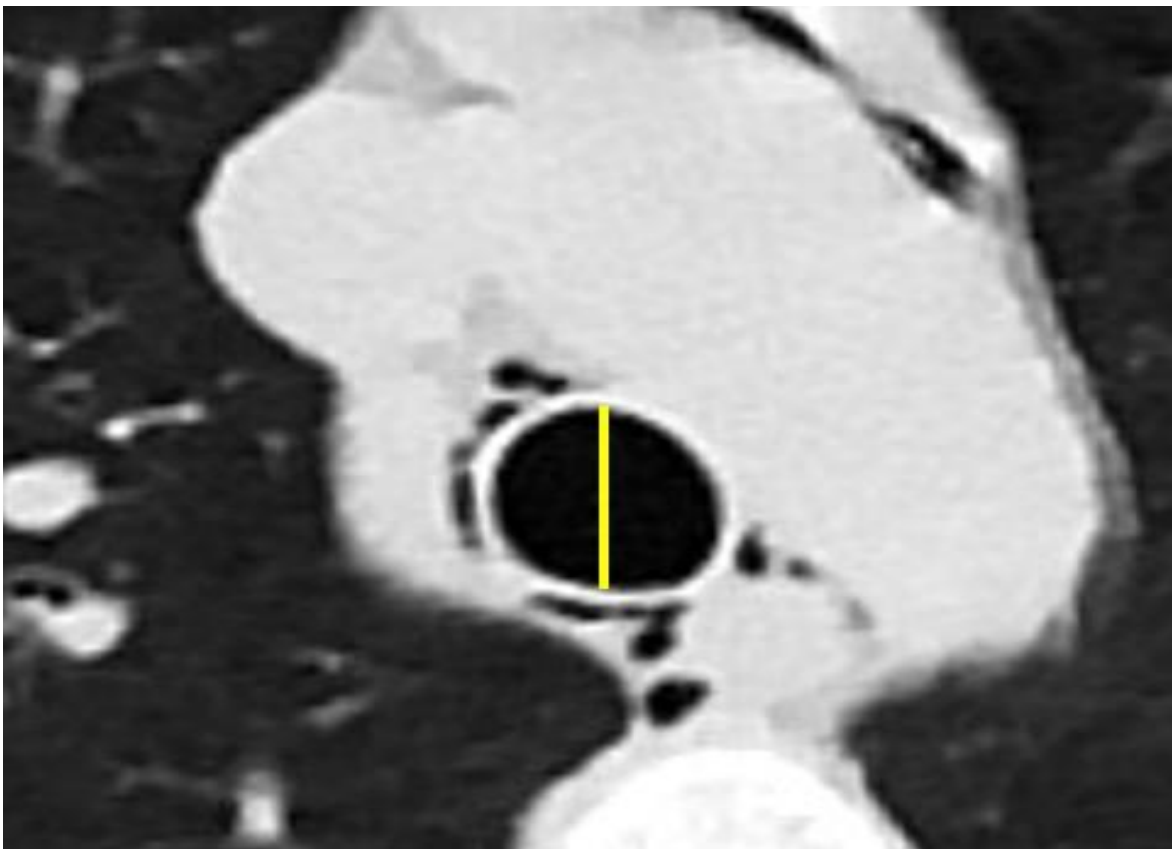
Measurement of the anteroposterior (AP) diameter of the trachea on an axial CT image, 2 cm proximal to the carina
